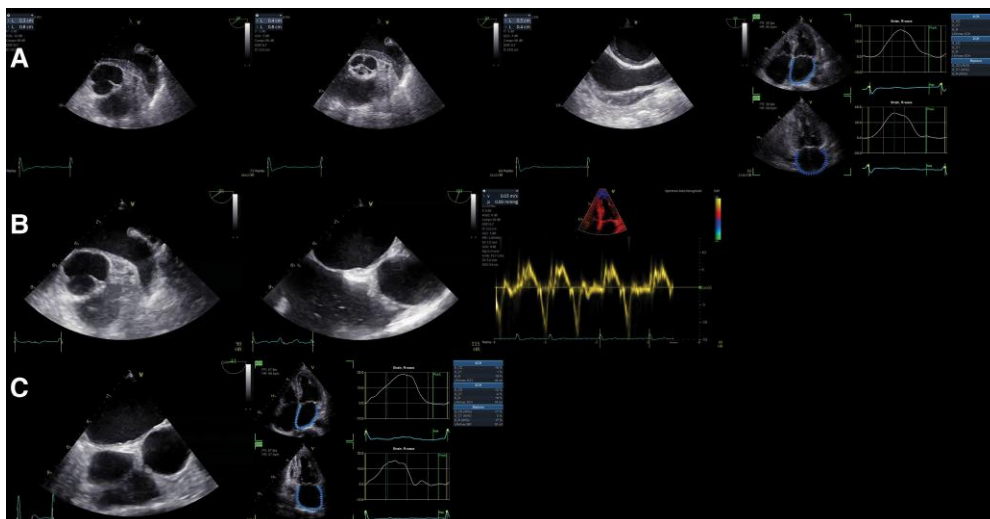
Transoesophageal echocardiography and left atrial strain before and after prednisolone treatment. (A) TOE and left atrial strain at second readmission. (B) TOE and a' velocity following prednisolone treatment at two-months follow-up. (C) TOE and left atrial strain at three-months follow-up after ended prednisolone treatment. TOE, Transoesophageal echocardiography.
